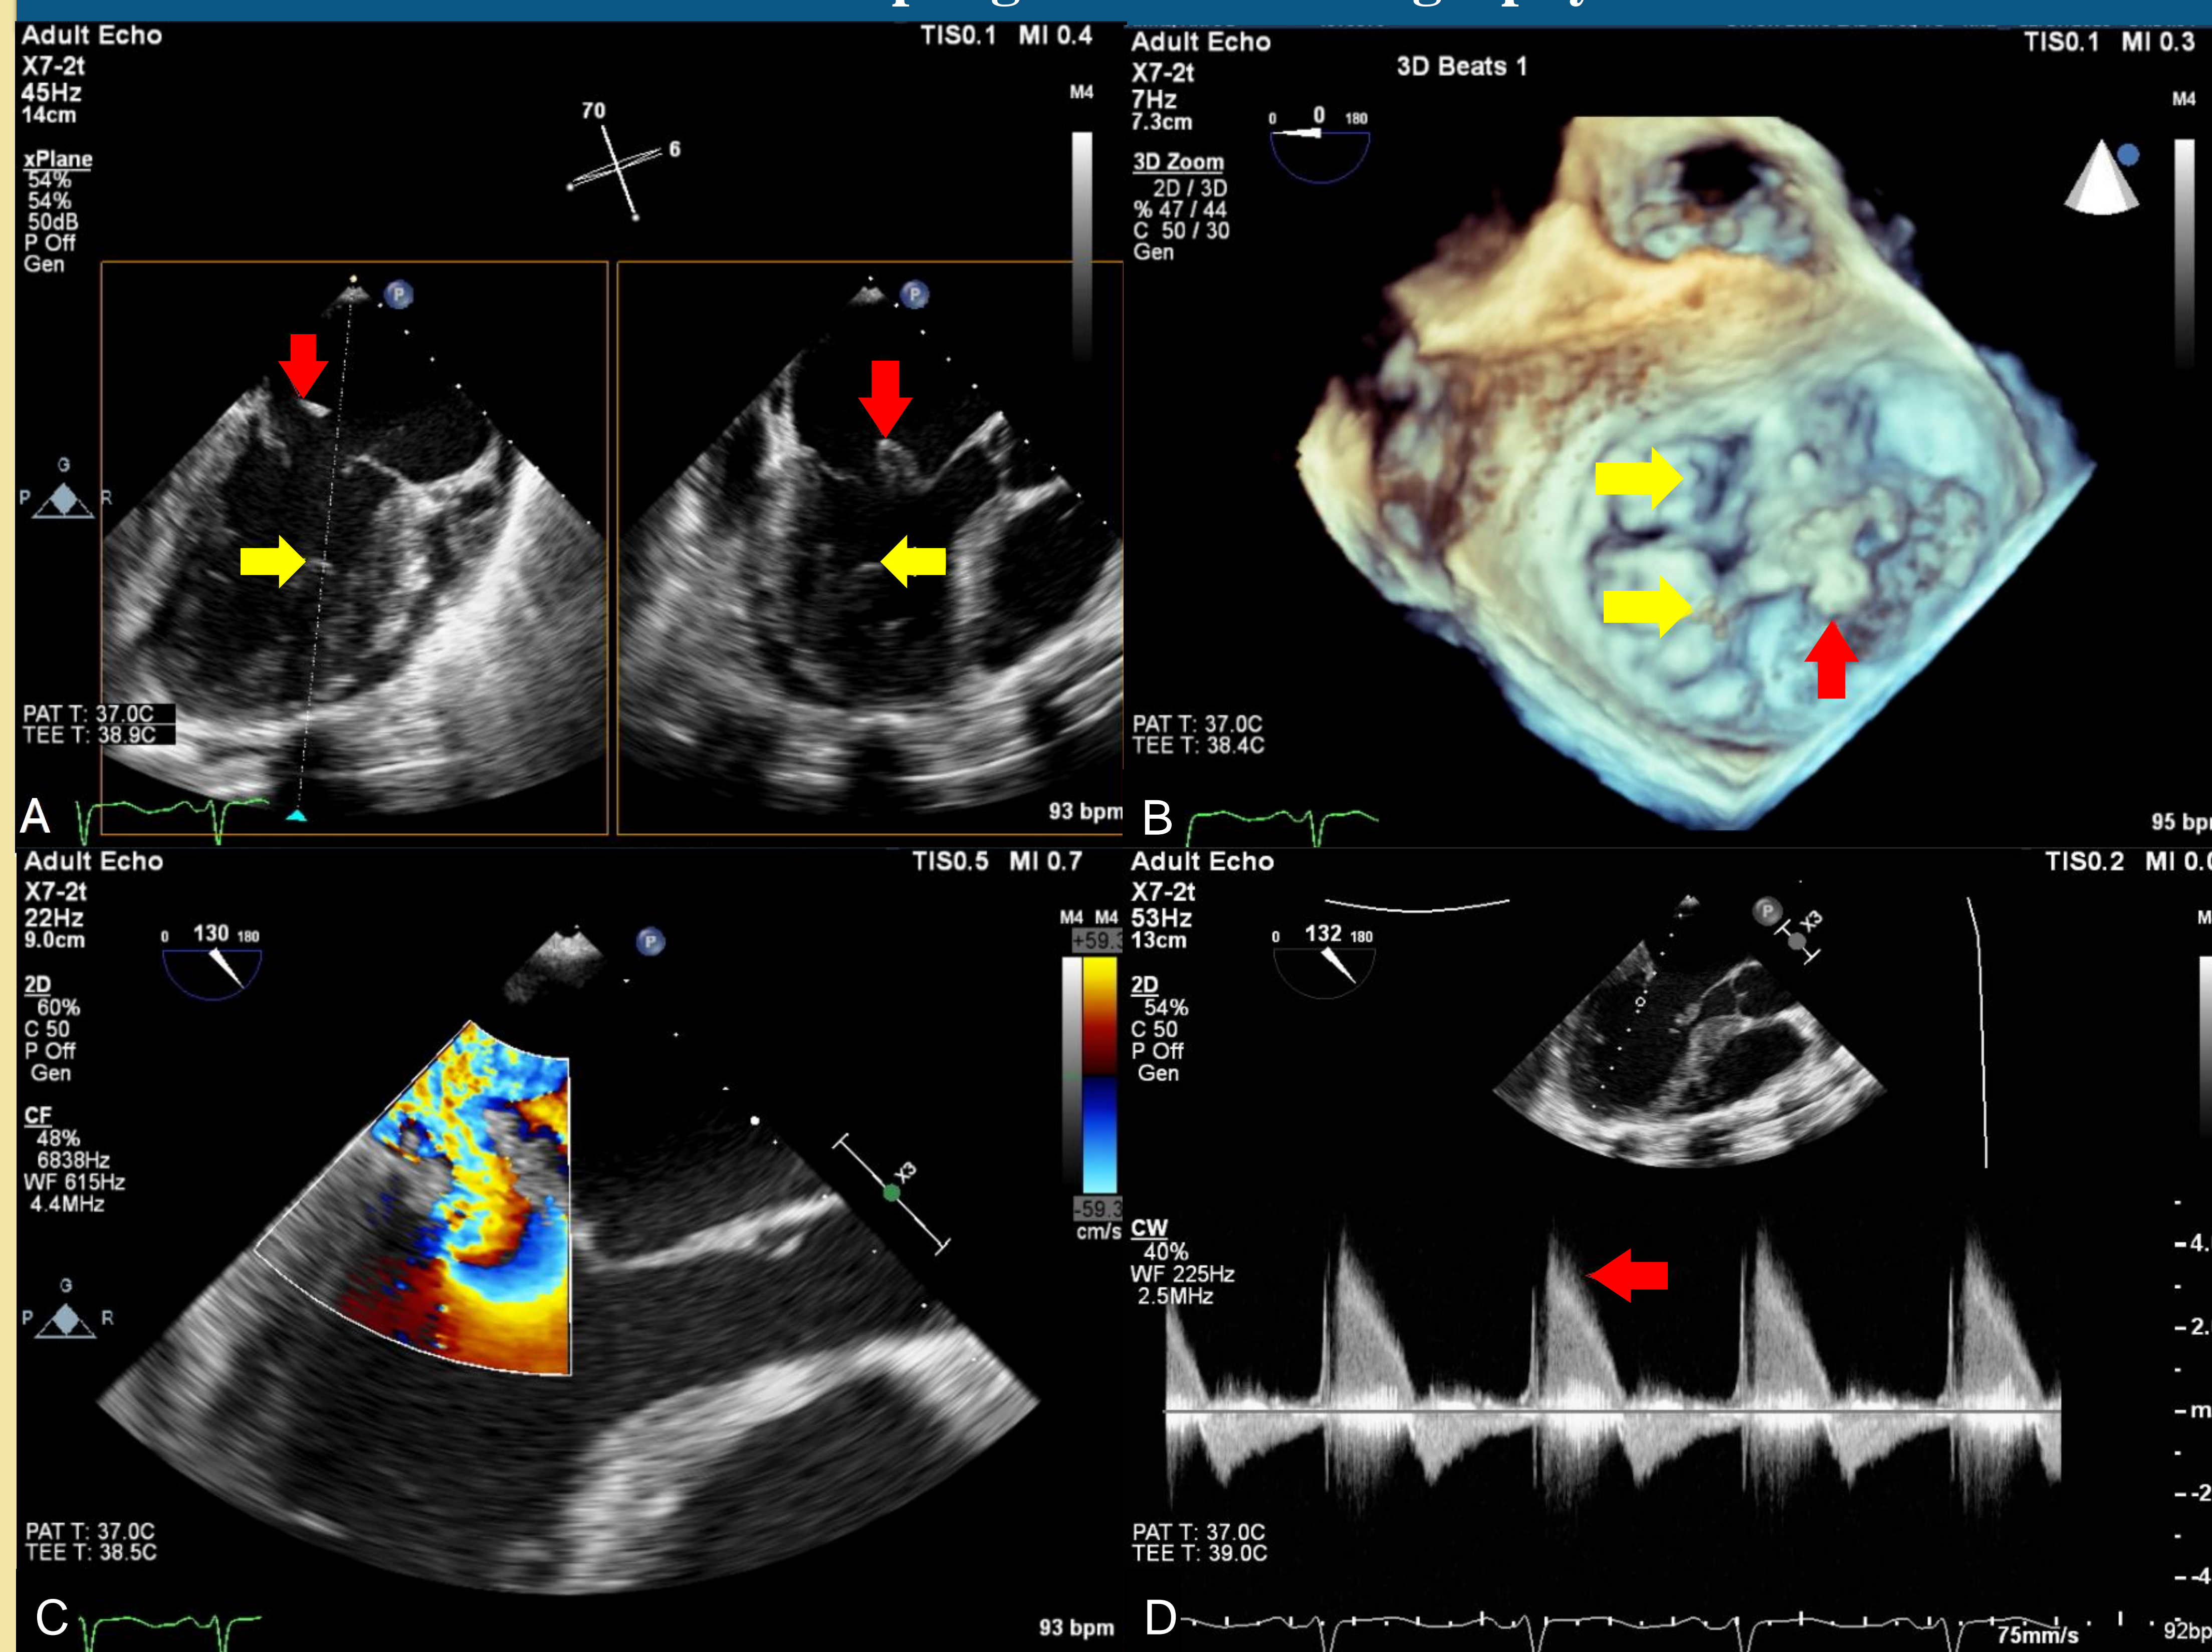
(A) Midesophageal view with X-plane. Head of papillary muscle (red arrows) ruptured from anterolateral papillary muscle (yellow arrows). (B) 3D surgeon's view with PMR (red arrow) and multiple vegetations (yellow arrows). (C) Midesophageal 3-chamber view with color Doppler. (D) Continuous wave Doppler signal through mitral valve is blunted (red arrow), known as the "cut-off" sign.
